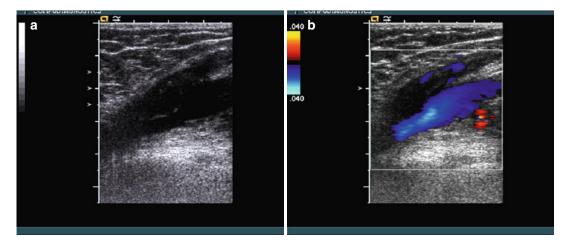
Thrombus extension after vein ablation is seen in gray scale (a) and Doppler (b) is the area without blue flow
